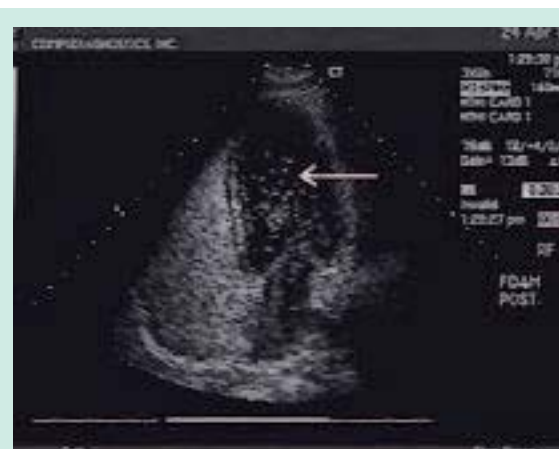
four chamber transthoracic echo showing left heart with bubbles from right heart within 10 seconds of initial injection of foam into peripheral leg vein (arrow-left heart chamber foam debris).
